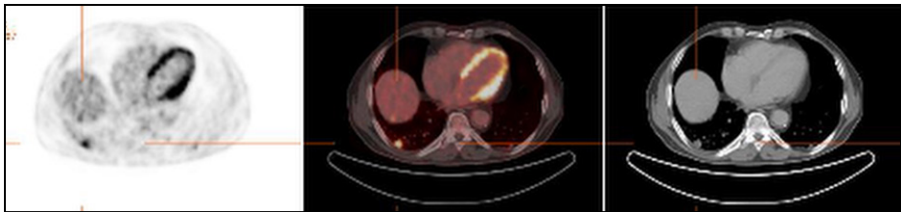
PET/CT fused image display with a PET image on the left showing a hot lesion at the border between the lung and rib cage. The fused image in the middle shows the location inside the lung close to the pleura; the CT image on the right confirms and permits close inspection of the position. Linked cursors point to the position of the lesion. The transparency factor α is 0.5.
